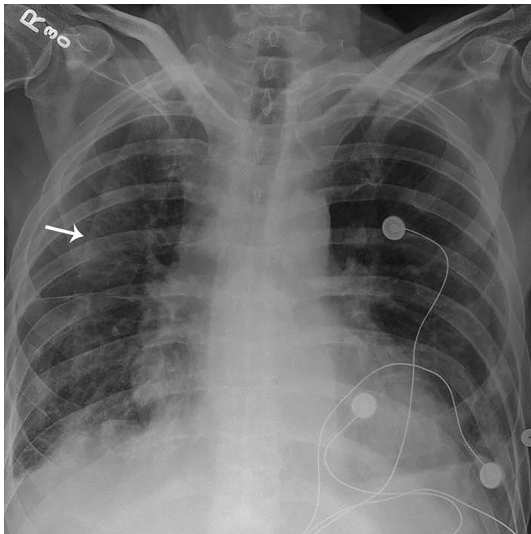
Single supine radiograph demonstrates the typical pattern of a skin fold. Note that the free edge is not a sharp thin line, but rather there is a gradual transition from less to more radiopacity until the increased density ends which creates the appearance of a line (arrow). This is the typical appearance of a skin fold and should not be mistaken for a pneumothorax
